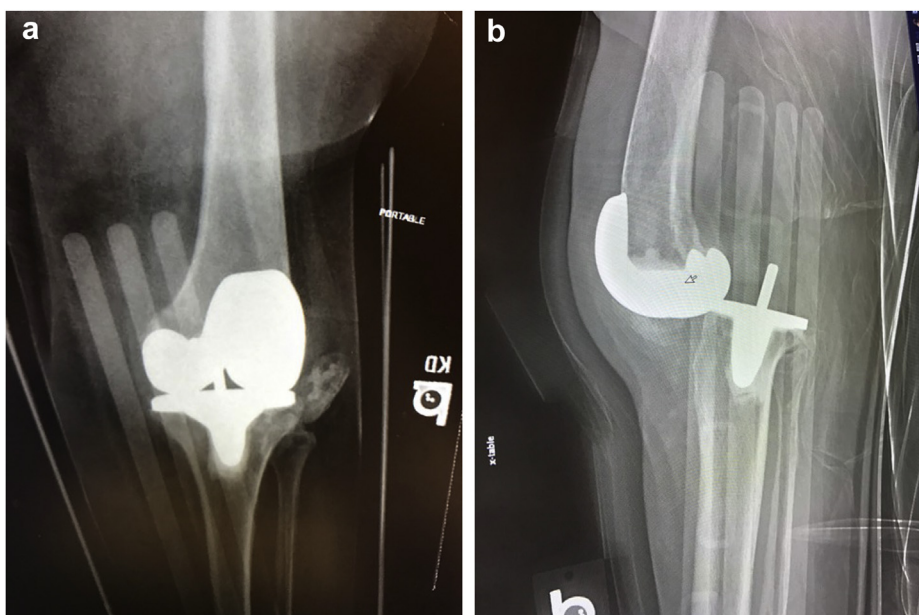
AP (a) and lateral (b) radiographs of left total knee arthroplasty after attempted closed reduction using manual traction and manipulation of the rotating platform under fluoroscopy. She was placed in a knee immobilizer. Postreduction radiographs demonstrating recurrent posterior dislocation.
